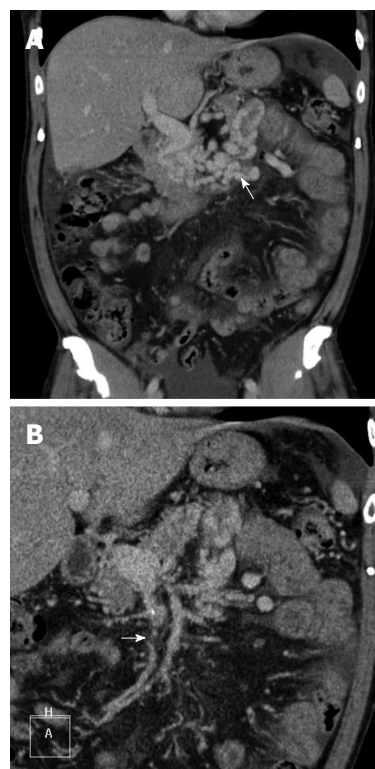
Computed tomographic scan reveals vascular tufts around the proximal jejunum (A, arrow), and thrombi are visible as hypodense lesions in the contrasted superior mesenteric vein (B, arrow).
